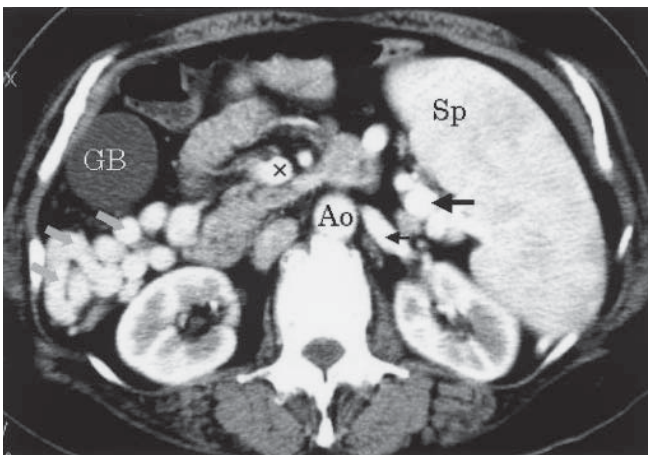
Abdominal computed tomography scan enhanced by contrast medium. Horizontal section at the level of splenic vein is shown. Splenomegaly, dilatation of the splenic vein (*large arrow*), medial and right colic veins (*gray arrows*) are found. Renal vein (*small arrow*) is also dilated and portorenal shunt is possibly present. *Sp*, spleen; *Ao*, aorta; *x*, superior mesenteric vein; *GB*, gall bladder
